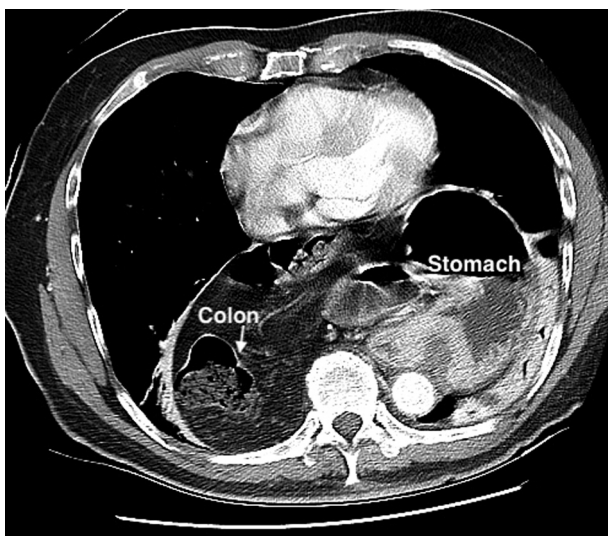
CT image showing a large paraesophageal hernia containing stomach and transverse colon (*white arrow*).
